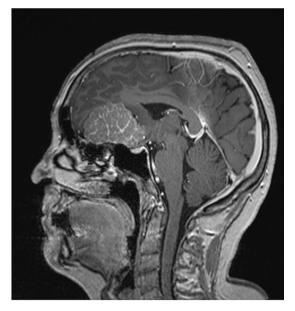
Axial and sagittal reconstructions of the preoperative MRI scan of the patient from Clinical case 2. An extra-axial frontobasal lesion is noted with heterogenous contrast-enhancement.
